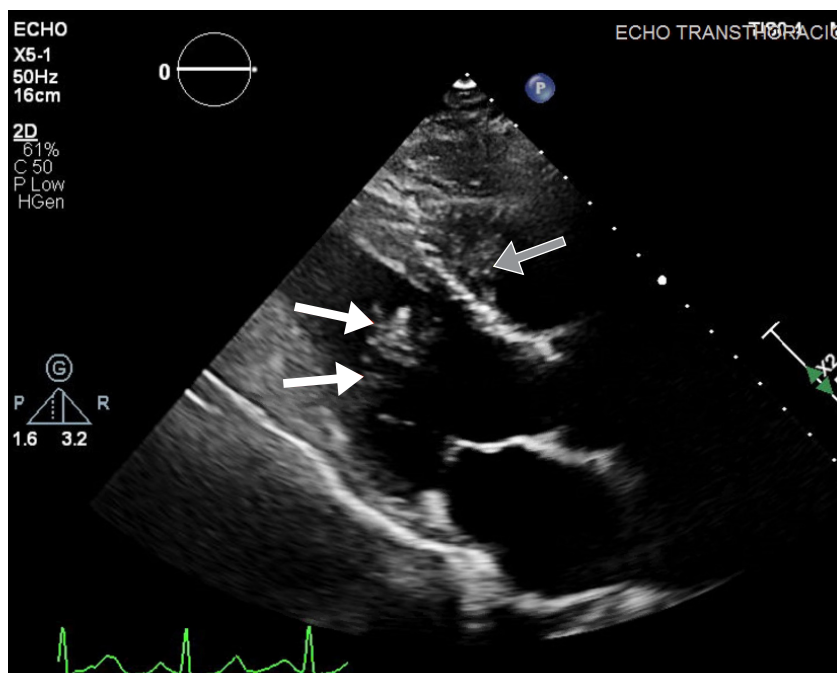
Transthoracic echocardiogram with a long parasternal view shows 2 hyperechoic masses within the left ventricle that measure 1.2×0.74 cm (top white arrow) and 3×1.4 cm (bottom white arrow). The right ventricle shows a mass of 1.1×1 cm (gray arrow).
